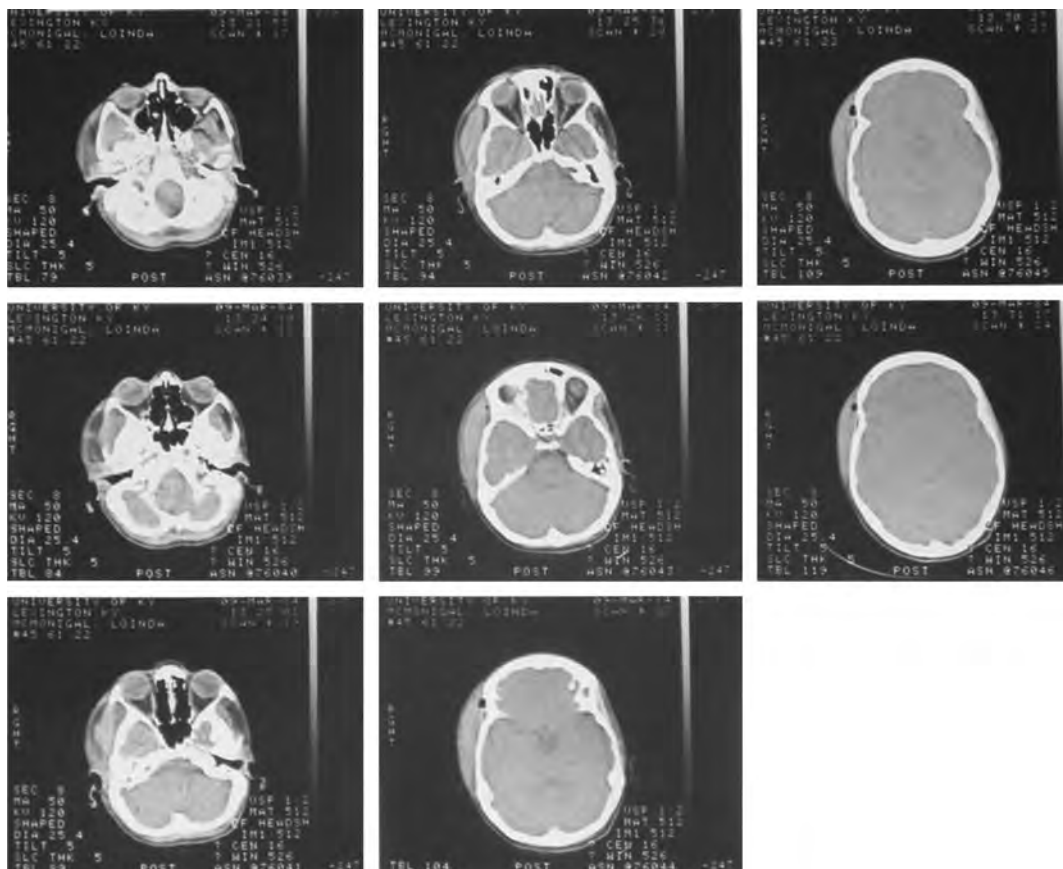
Head and face CT of the patient seen in Fig. 26. Note the right deep temporal space abscess.
